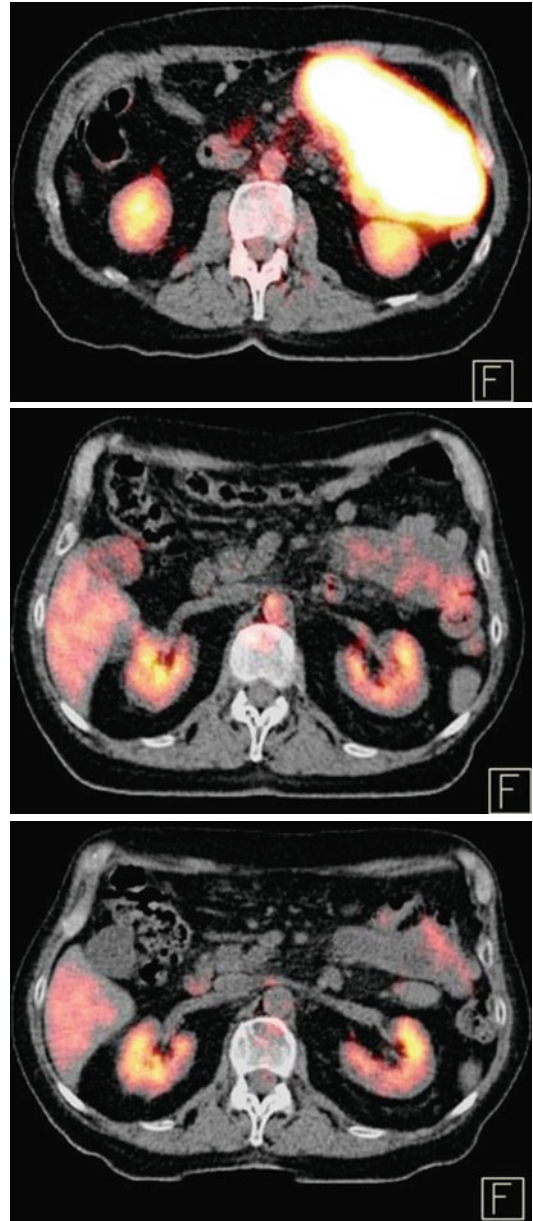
Superiority of metabolic evaluation of treatment response compared to CT imaging. Gradual significant reduction of the size of the lesion in the CT images, with early absence of metabolic activity
